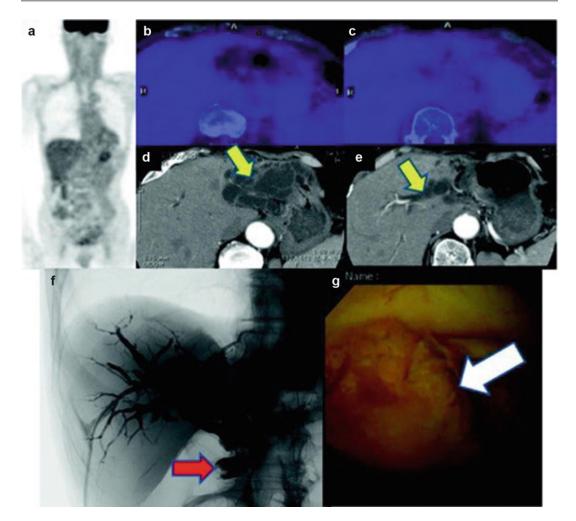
Mucin-producing extrahepatic bile duct tumor. PET/CT does not show abnormal [18 F]FDG accumulation (a-c). Contrast-enhanced CT shows bile duct dilatation in bilateral lobe (d, e; *yellow arrows*). Cholangiography shows extra- and intrahepatic biliary dilatation and filling
